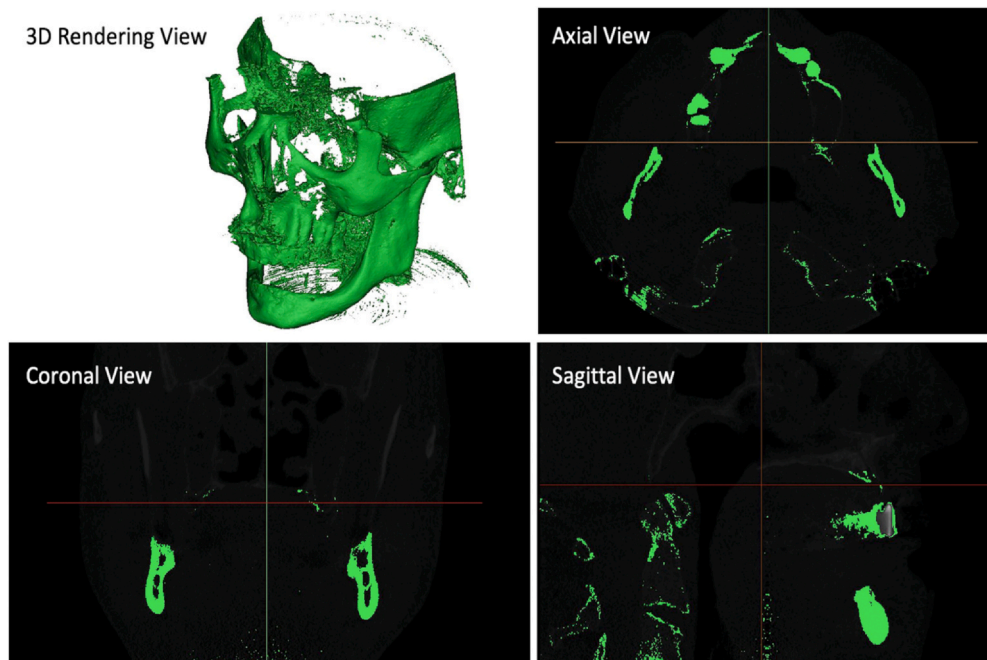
Cone beam computed tomography-based 3-dimensional anatomic reconstruction of edentulous mandible with advanced resorption.
